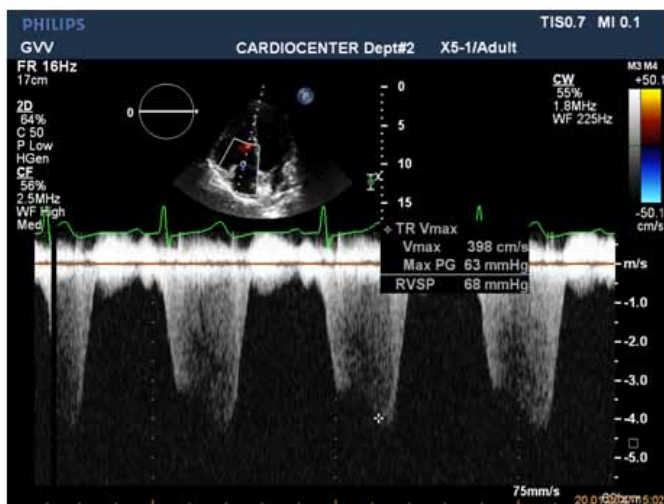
Continuous wave Doppler study of the tricuspid regurgitation for evaluating of systolic PAP (68 mm Hg).
